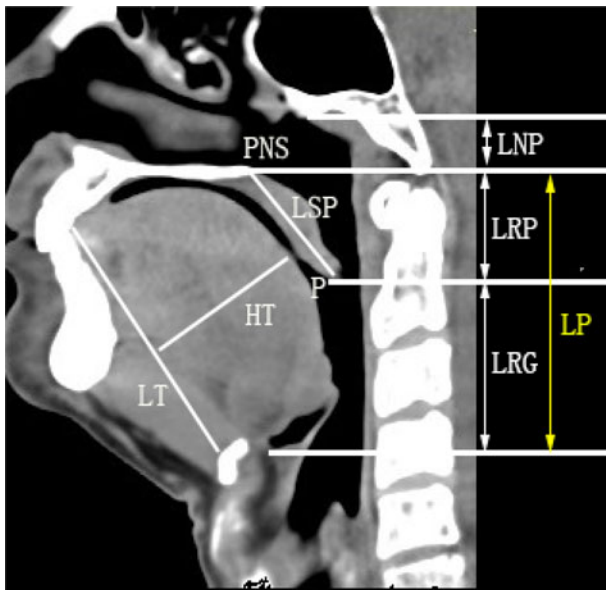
Mid-sagittal computed tomography scan denoting: length of nasopharyngeal region (LNP); length of retropalatal region (LRP); length of retroglossal region (LRG); length of pharyngeal airway (LP), which can be divided to retropalatal length and retroglossal length; length of soft palate (LSP); tip of soft palate (P); posterior nasal spine (PNS); length of tongue (LT); and height of tongue (HT).
